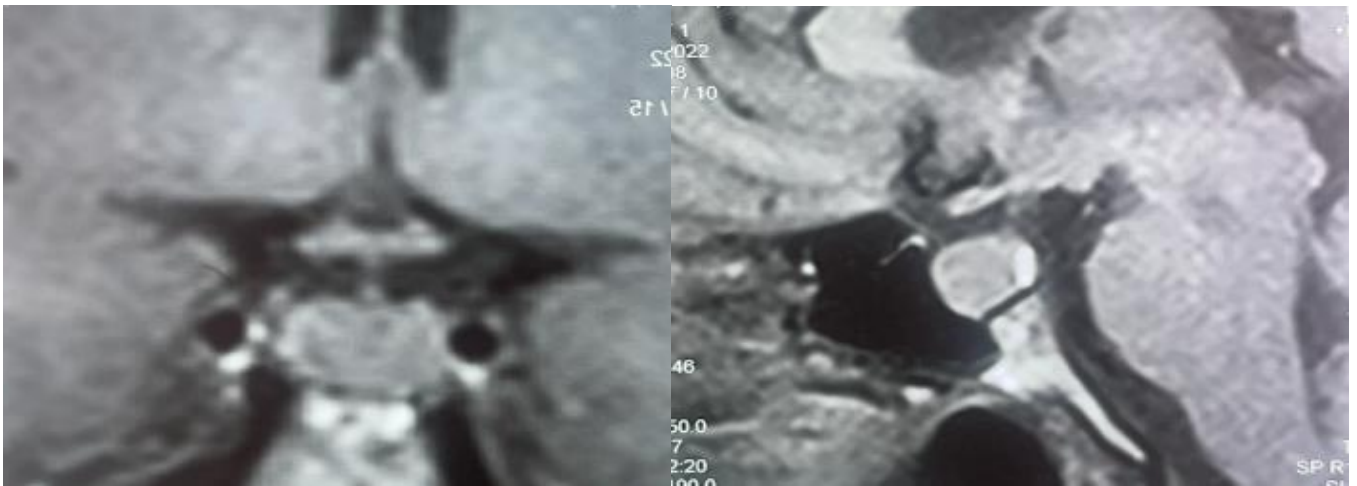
Preoperative sagittal and coronal hypothalamic-pituitary MRI showing a sellar tumor process measuring 12.7x9.2x8.8 mm
